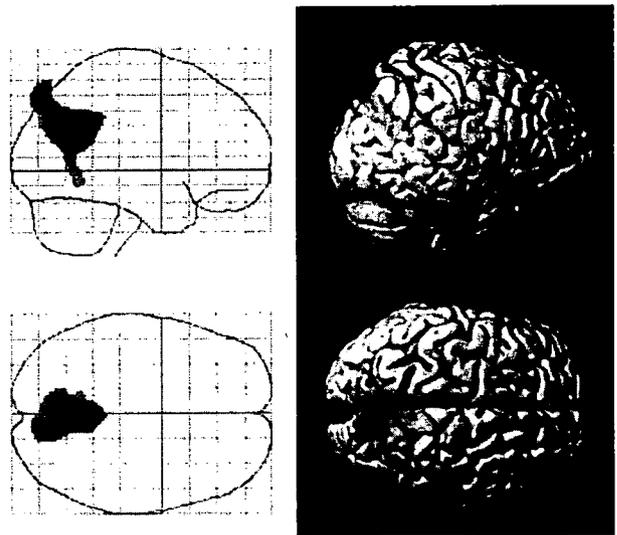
軽度認知障害の FDG-PET 統計画像診断
